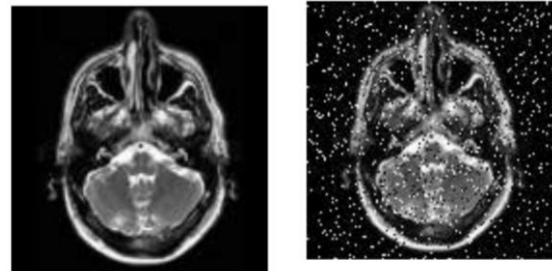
Original and Noise effected sample in MRI processing
